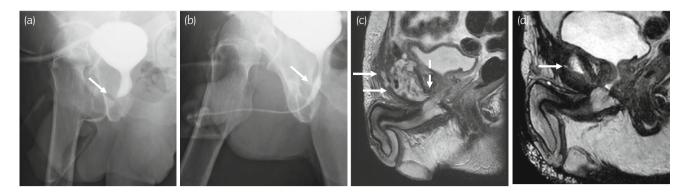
Radiological findings of case 3. (a) Retrograde urethrography showed urethral stenosis at the bulbomembranous junction (arrow). (b) Retrograde urethrography after EPA showed a wide urethral lumen without extravasation. (c) T2-weighted MRI in the sagittal plane showed USF from the anastomosis site (dotted arrow) to the pubic symphysis (arrows). (d) T2-weighted MRI in the sagittal plane after the debridement of necrotic pubic bone (arrow).
